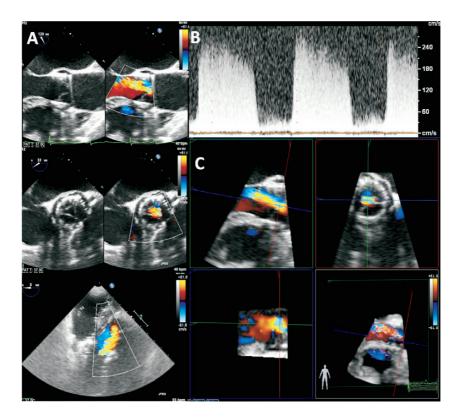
An example of moderate-to-severe transvalvular aortic regurgitation (AR) after TAVI, assessed semi-quantitatively using Doppler parameters: a jet width that occupied 45% of the LVOT diameter (A), a dense CW Doppler signal and a steep jet deceleration rate (B). 3-dimensional colour-coded Doppler permits quantitative evaluation of AR using multiplanar reconstruction by planimetry of the regurgitant vena contracta area (C), which is performed by selecting the best frame to visualise the AR jet. The 3-D dataset was manually cropped to provide a cross-sectional plane through the vena contracta of the AR jet, perpendicular to the direction of the jet. From the en face view of the vena contracta and selecting the plane with the narrowest cross-sectional area of the regurgitant jet, planimetry of the vena contracta can be performed.
